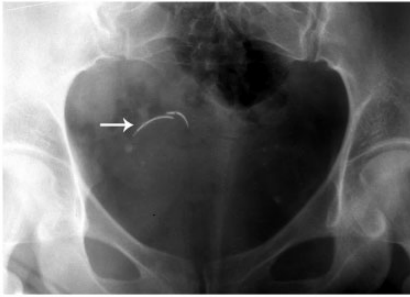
Retained needle on pelvic X-ray examination.
